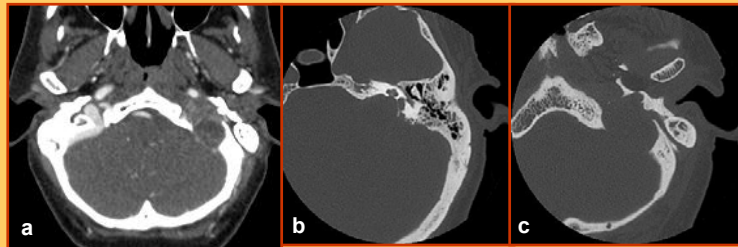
Axial CT a) post-contrast, b) and c) bone window images
